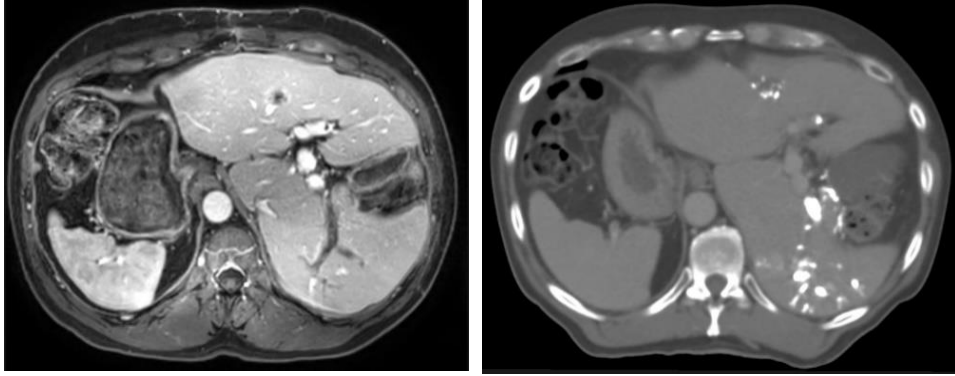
Example of different imaging modalities, transversal view. Top left: MR image; top right: CT image.
